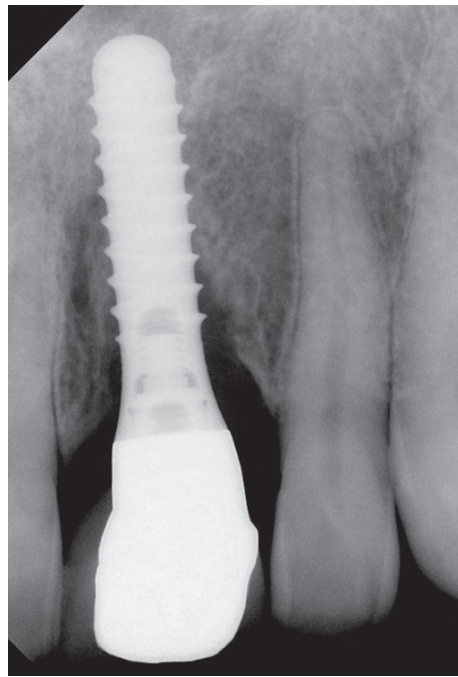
This radiograph reveals the loss of bone to the fourth thread on the distal of the implant caused by peri-implantitis.
